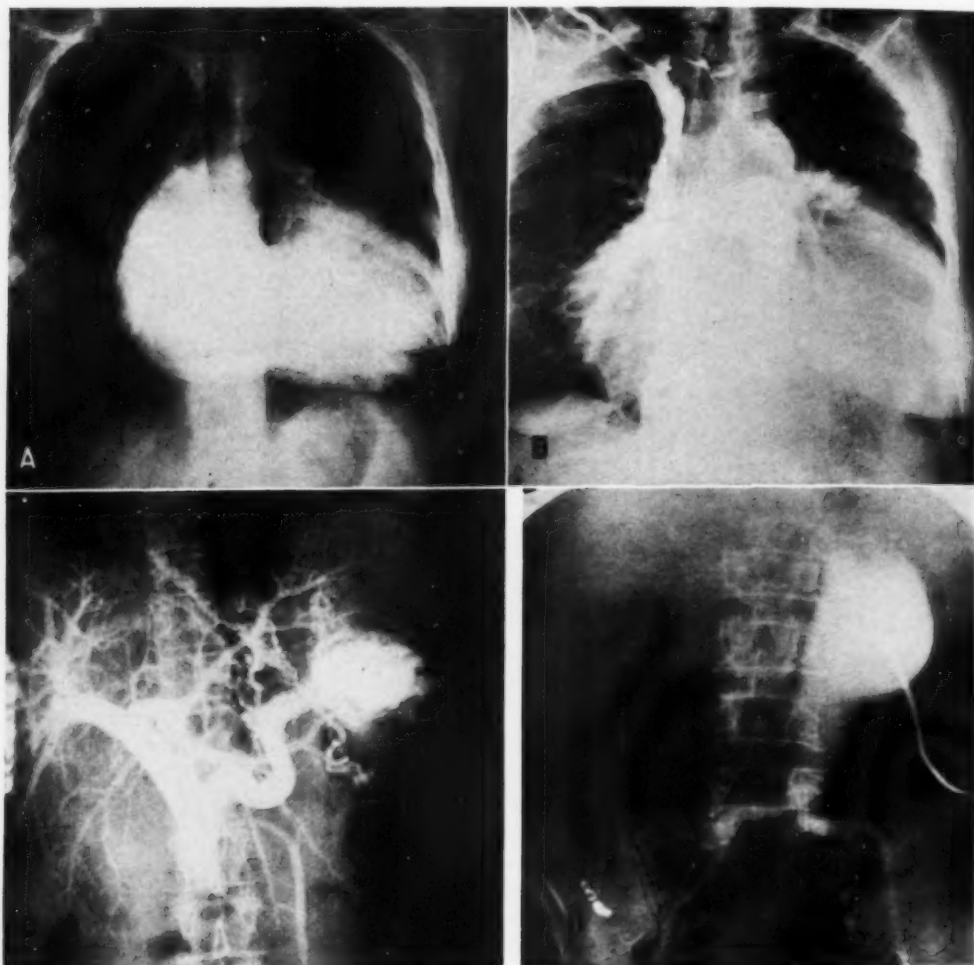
Rapid serial roentgenography utilizing 12×12 -inch roll film.
